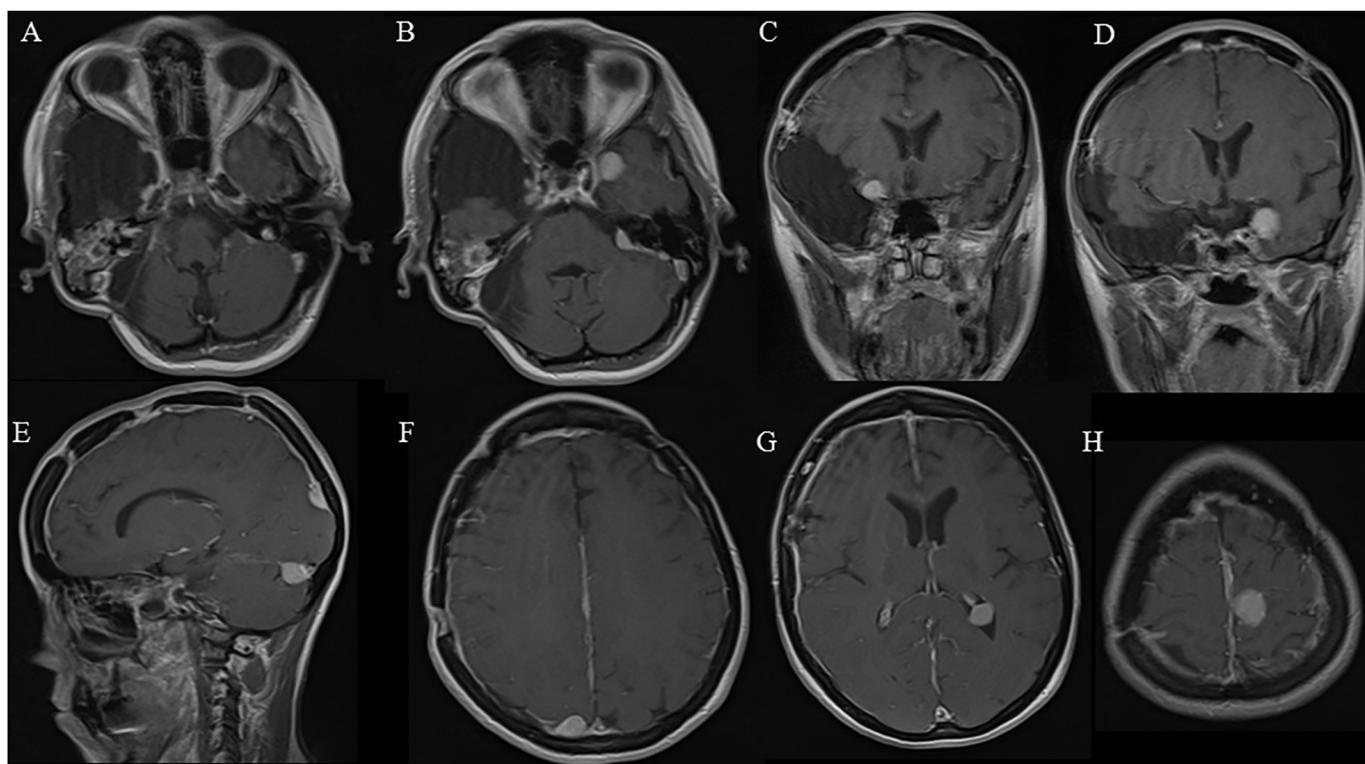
Five-year follow-up brain MRI (T1 + Gd).
